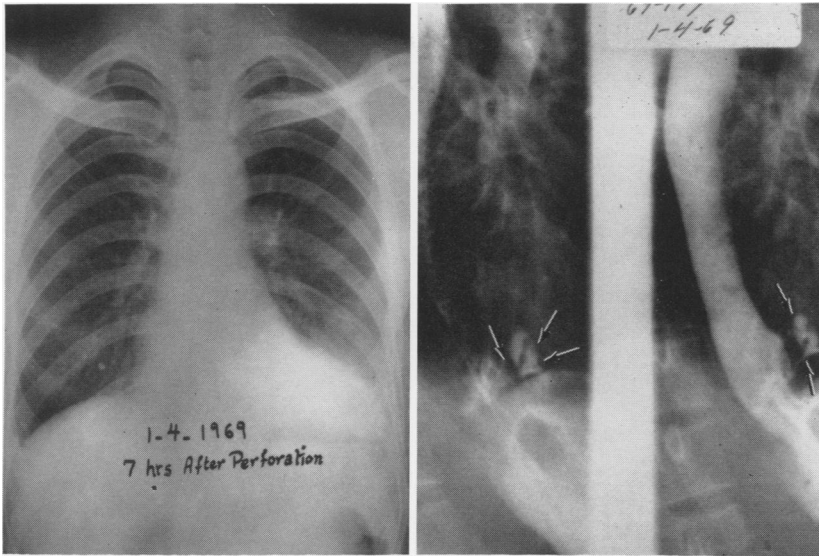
Plain x-ray view of the chest from Case 2 seven hours after spontaneous rupture of the esophagus. Note, slight blunting of the left costodiaphragmatic angle. B. Gastrografin esophagogram taken at the left lateral decubitus position shows leakage of contrast material at the left lower esophageal area (arrows).
